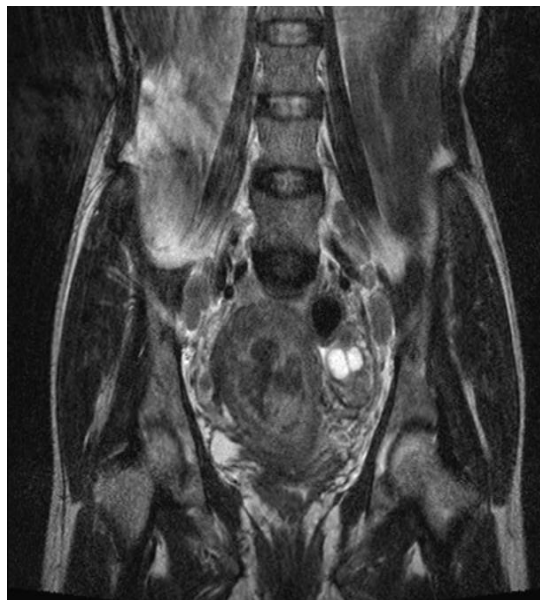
MRI coronal T2 W image of endometrial carcinoma. Reveals bulky uterus with ill defined heterogenous altered signal intensity mass lesion within the endometrial canal focally invading the myometrium. Also multiple enlarged bilateral common iliac lymph nodes seen.
